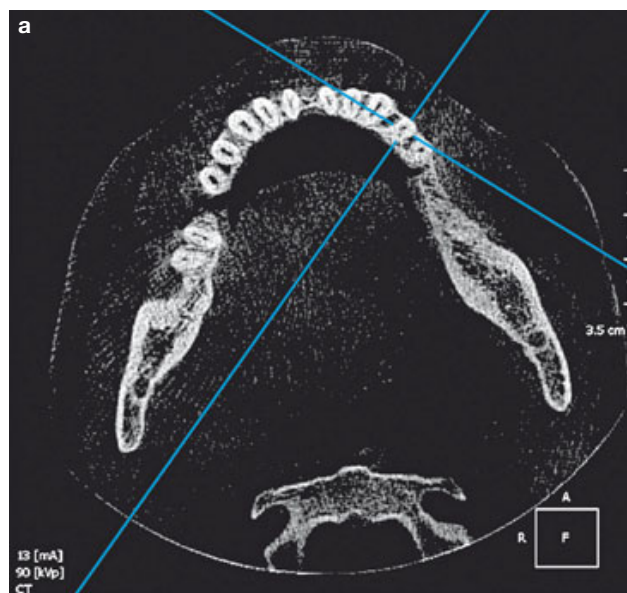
Cross-sectional CBCT images of the left mandibular first premolar with two clearly distinguished roots and canals: a) axial plane; b) sagittal plane; c) coronal plane.
